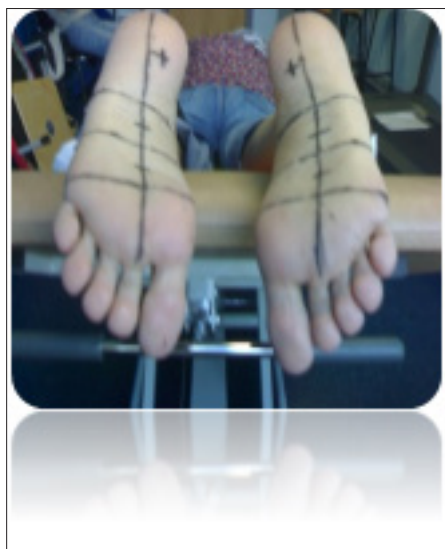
Position of subject for ultrasound scanning
